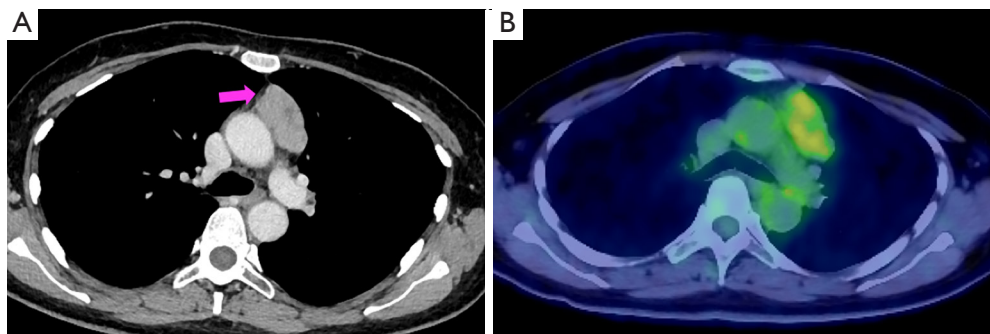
A case of a 53-year-old female with 5-cm thymoma. (A) CT revealed a 50 mm × 40 mm well-circumscribed, lobulated mass at the left anterior mediastinum (arrow); (B) FDG-PET showed abnormal uptake in the tumor with a maximal standardized uptake value (SUVmax) of 3.2. CT, chest computed tomography; FDG, fluorodeoxyglucose; PET, positron emission tomography.
